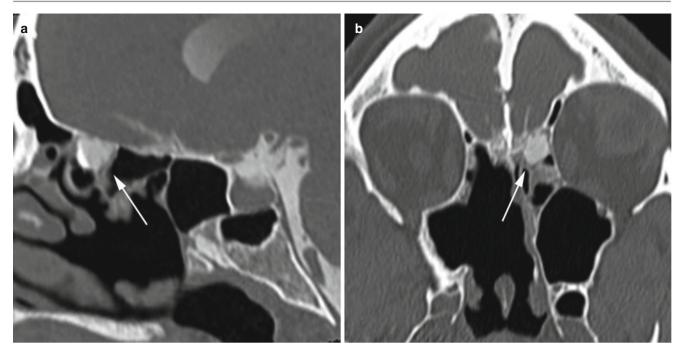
CSF leak. (a) Sagittal CT cisternogram image. (b) Coronal CT cisternogram image. Postoperative changes from prior right ethmoid resection and medial maxillary antrostomy are present. In both
